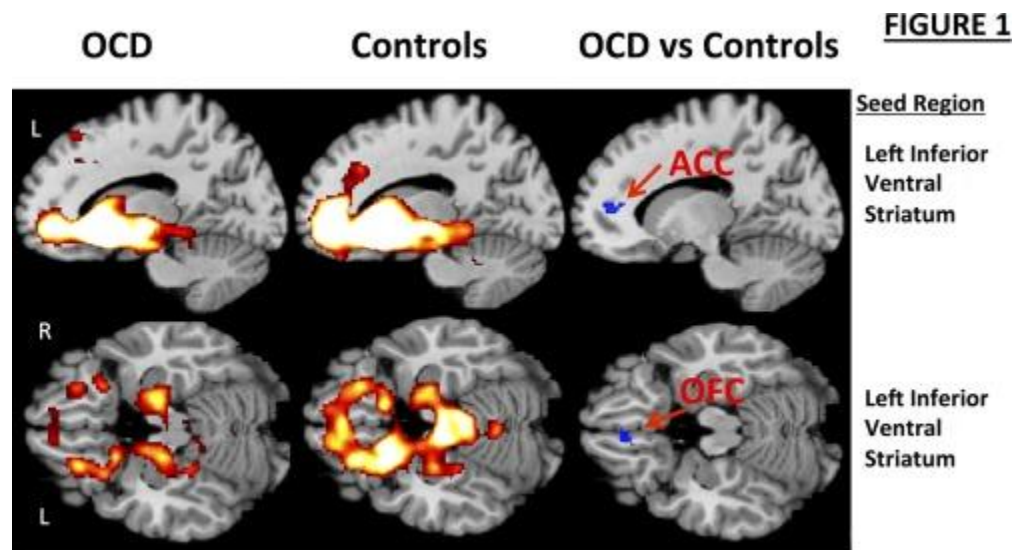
Resting state functional connectivity MRI of OCD patients vs healthy controls
